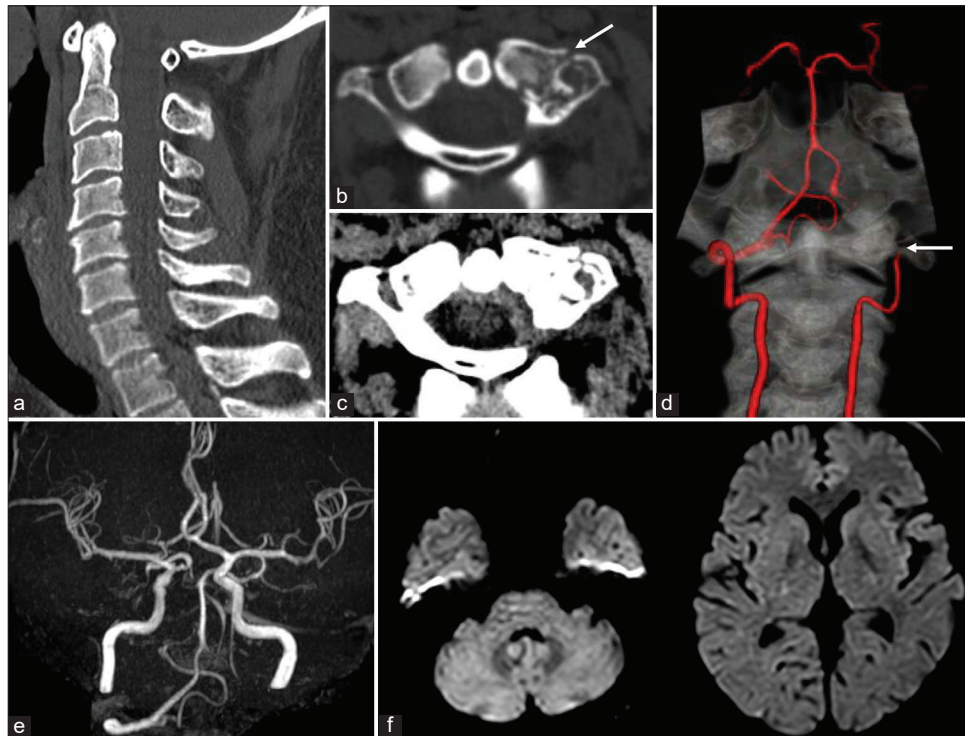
Imaging findings on admission. Cervical spine computed tomography (CT) showing no cervical dislocation or spinal canal stenosis (a), but there were fractures in the left lateral mass and transverse process of Atlas, with no high density area suggestive of a thrombus in the foramen transversum. The white arrow indicates the fractures in the left lateral mass and transverse process of Atlas (b and c). CT angiography showing the left vertebral artery occluded at the level of the foramen transversum of Atlas. Both vertebral arteries are similar in diameter, and the left vertebral artery V4 segment and left posterior inferior cerebellar artery are depicted through the right vertebral artery. White arrow indicates occlusion (d). Magnetic resonance angiography showing no blood flow signal in the left vertebral artery (e). Diffusion-weighted magnetic resonance imaging showing no acute cerebral infarction (f).
